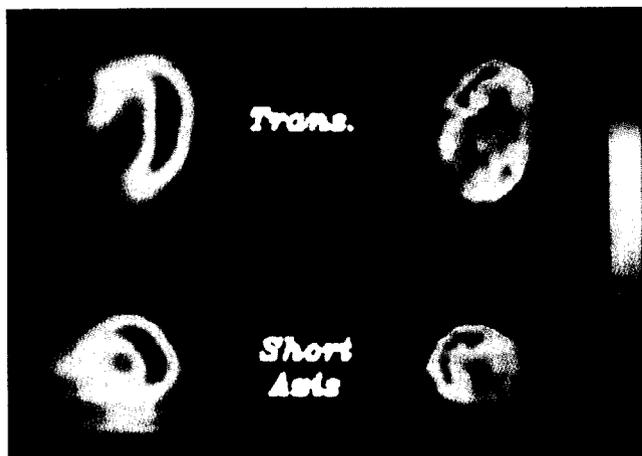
Patient 10. Rest myocardial perfusion (left) and positron emission tomographic (right) scans. Left, A perfusion defect involving the septum and anterior wall is evident on technetium-99m methoxyisobutyl isonitrile single-photon emission computed tomography. Right, Fluorine-18 fluorodeoxyglucose uptake is observed within the underperfused area at positron emission tomography. Trans = transaxial.
